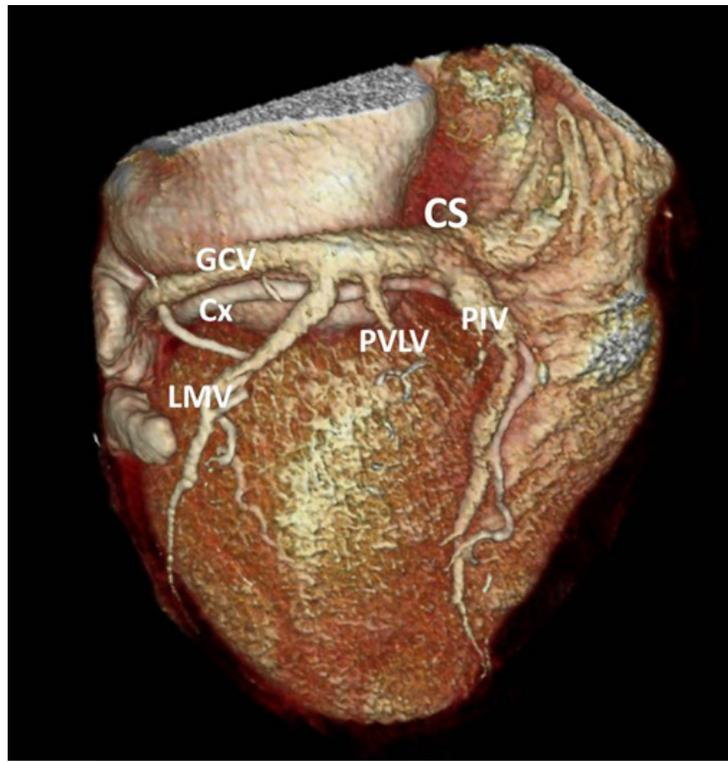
Assessment of cardiac venous anatomy with multi-detector row computed tomography. The 3-dimensional volume rendering shows the posterior aspect of the heart with the coronary sinus (CS) and its tributary branches: the posterior interventricular vein (PIV), the posterior vein of the left ventricle (PVLV) and the lateral marginal vein (LMV). Note the parallel course of the coronary sinus and the circumflex coronary artery (Cx)
